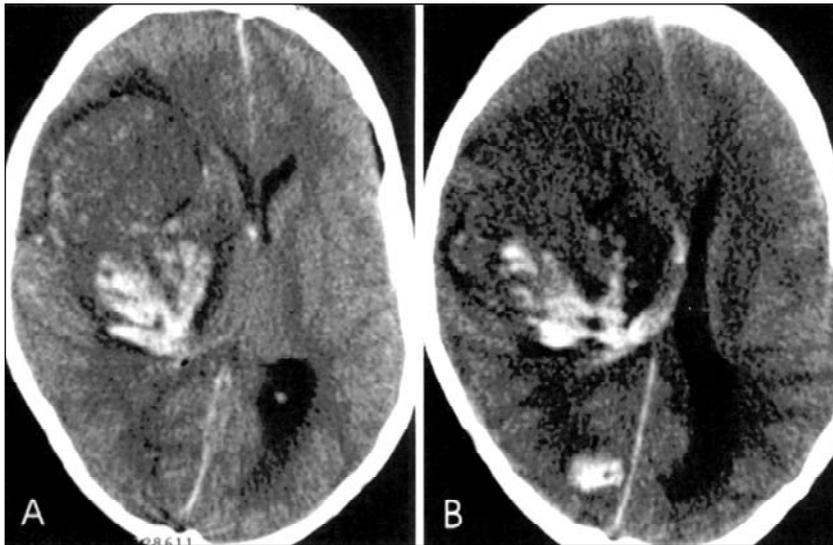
In A, CT scan demonstrates a large heterogeneous hematoma in the right fronto-temporal region, with hypo and hyperdense components. In B, CT scan shows an additional small parietal hematoma at the right, and severe midline shift.
